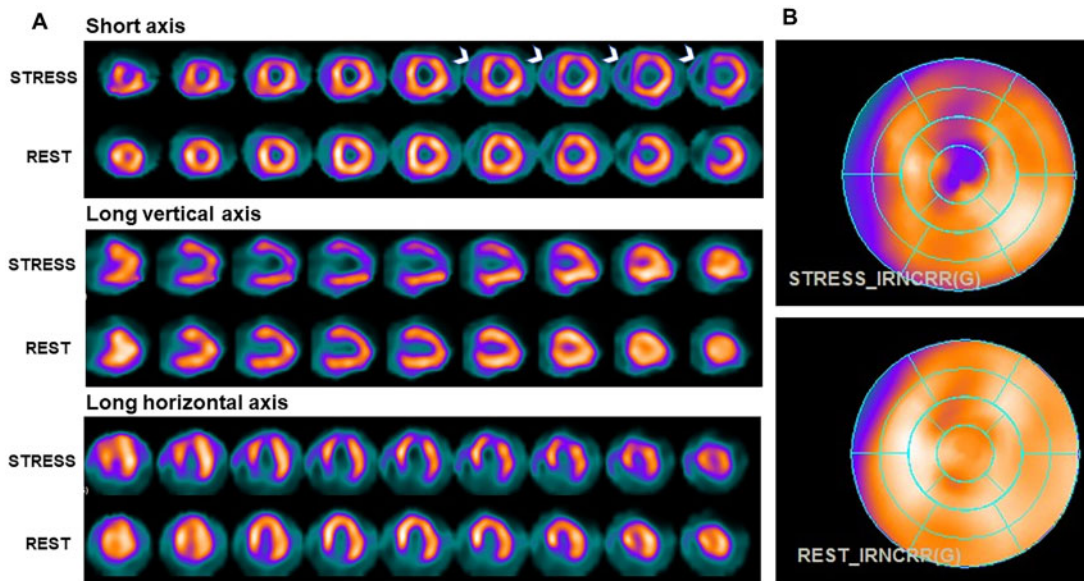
^{99m}Tc -MIBI gated-SPECT/CT in Patient 1. Tomographic (A) and polar maps (B) perfusion images obtained during stress and at rest showed a reversible perfusion defect suggestive of mild/moderate ischaemia extending through anterior wall, upper septum, and apex. Post-stress and rest left ventricular ejection fraction were 47% and 70%. Note the most prominent right ventricle cavity after regadenoson stress (arrowheads).
